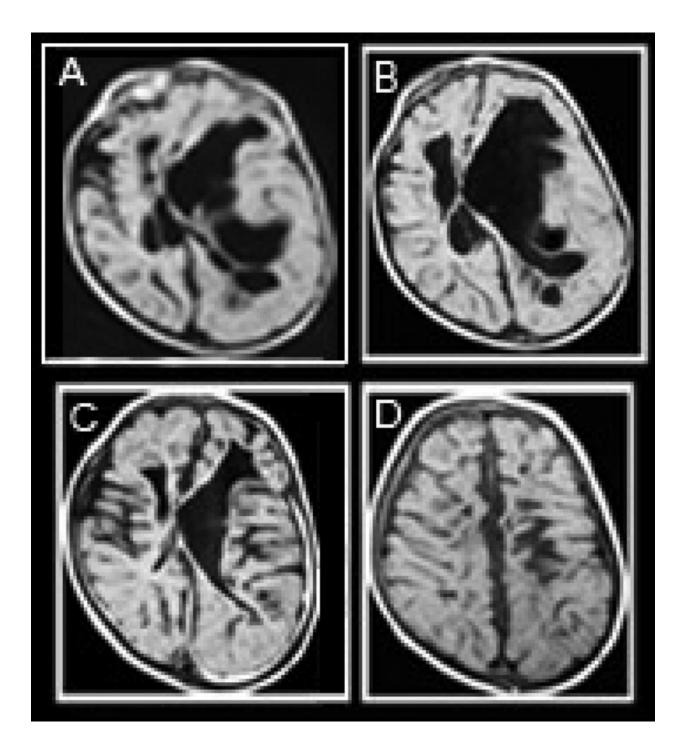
A, B, preoperative axial MR imaging of a 7 months old male patient with multiloculated hydrocephalus due to intrauterine toxoplasmosis infection. C, axial MR imaging performed 3 months after surgery showing improvement of hydrocephalus. D, axial MR imaging performed 1 year after surgery showing complete resolution of hydrocephalus [Reprinted with permission from El-Ghandour NM (2008). Endoscopic cyst fenestration in the treatment of multiloculated hydrocephalus in children. *J Neurosurg Pediatr*, Vol.1, No. 3, (March 2008), pp:217-222, ISSN 1933-0707].
